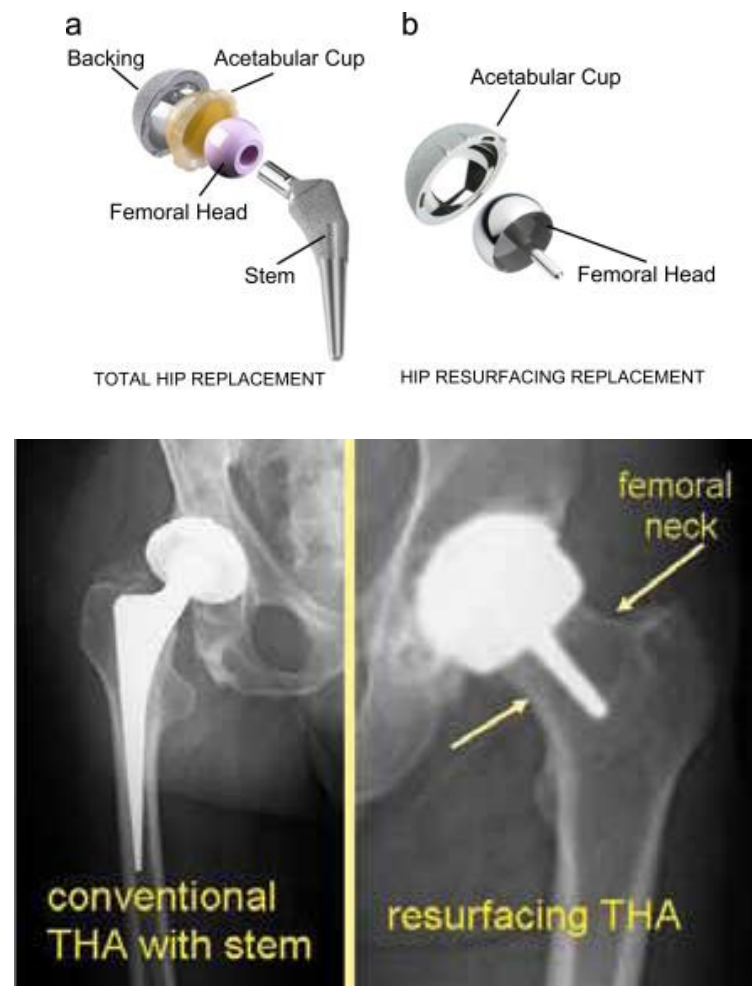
A Total Hip Replacement and (b) a Hip Resurfacing device and their respective X-ray images (Mattei et al., 2011, Holzwarth and Cotogno, 2012)
